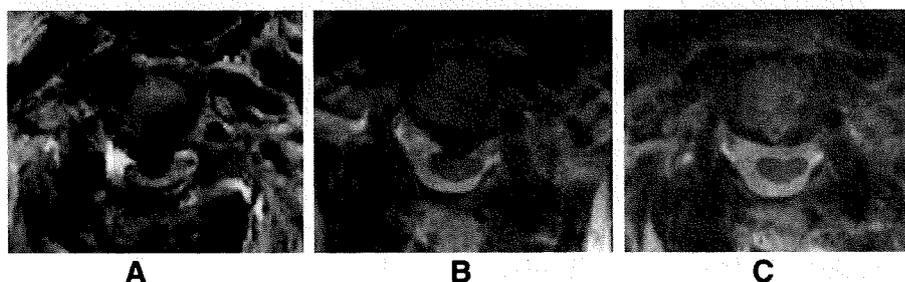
Case 3. Axial T2-weighted MR image at C2/3. A, Preoperative image. B, Image taken 6 weeks after posterior decompression. C, Image taken 1 week after anterior removal of the herniation.
